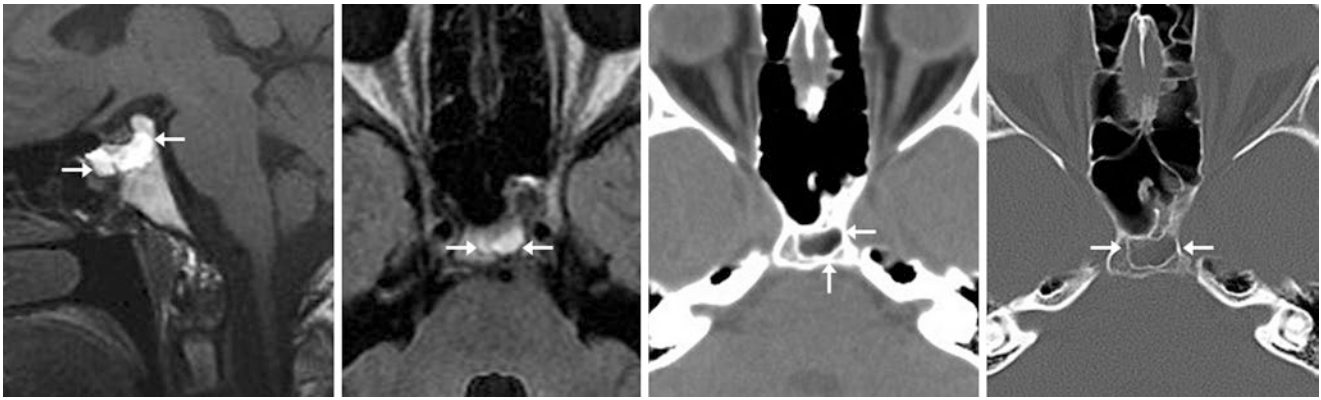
A 19 year old in whom an incidental basisphenoid lesion was noted on a sagittal T1WI MRI (*left*). Axial FLAIR (*left middle*) depicted a well-circumscribed, bright clival lesion (*arrows*) with bright T1 signal exceeding that of adjacent bone marrow. A CT scan (*right images*) confirmed fat within the mass and a thin sclerotic rim, consistent with arrested pneumatization of the sphenoid sinus (*Courtesy of Kirk M. Welker, MD, Mayo Foundation for Medical Education and Research, Rochester, MN, USA.*)
